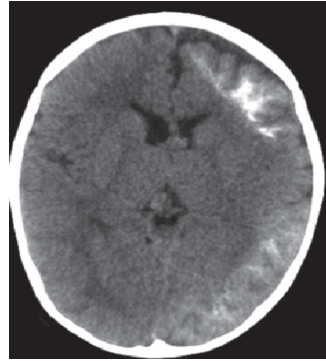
Non-contrast CT brain showing subcortical white matter calcification
